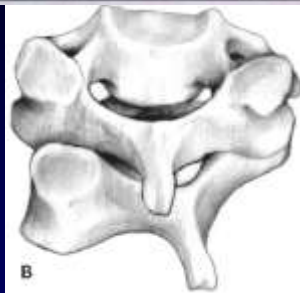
Flexion-distraction injuries of the lower cervical spine. A, bilateral facet dislocation. Lateral cervical spine radiograph showing bilateral facet dislocation of C6 on C7. This pattern of injury results from disruption of the supraspinous and interspinous ligaments, facet capsules, ligamentum flavum, posterior longitudinal ligament, and the dorsal portions of the annulus fibrosus. The soft tissue damage can be associated with fractures of the superior articular processes. B, unilateral facet dislocation. This injury is usually caused by the combination of flexion and rotational forces. The addition of shear or compressive forces can cause fracture of the articular process.
